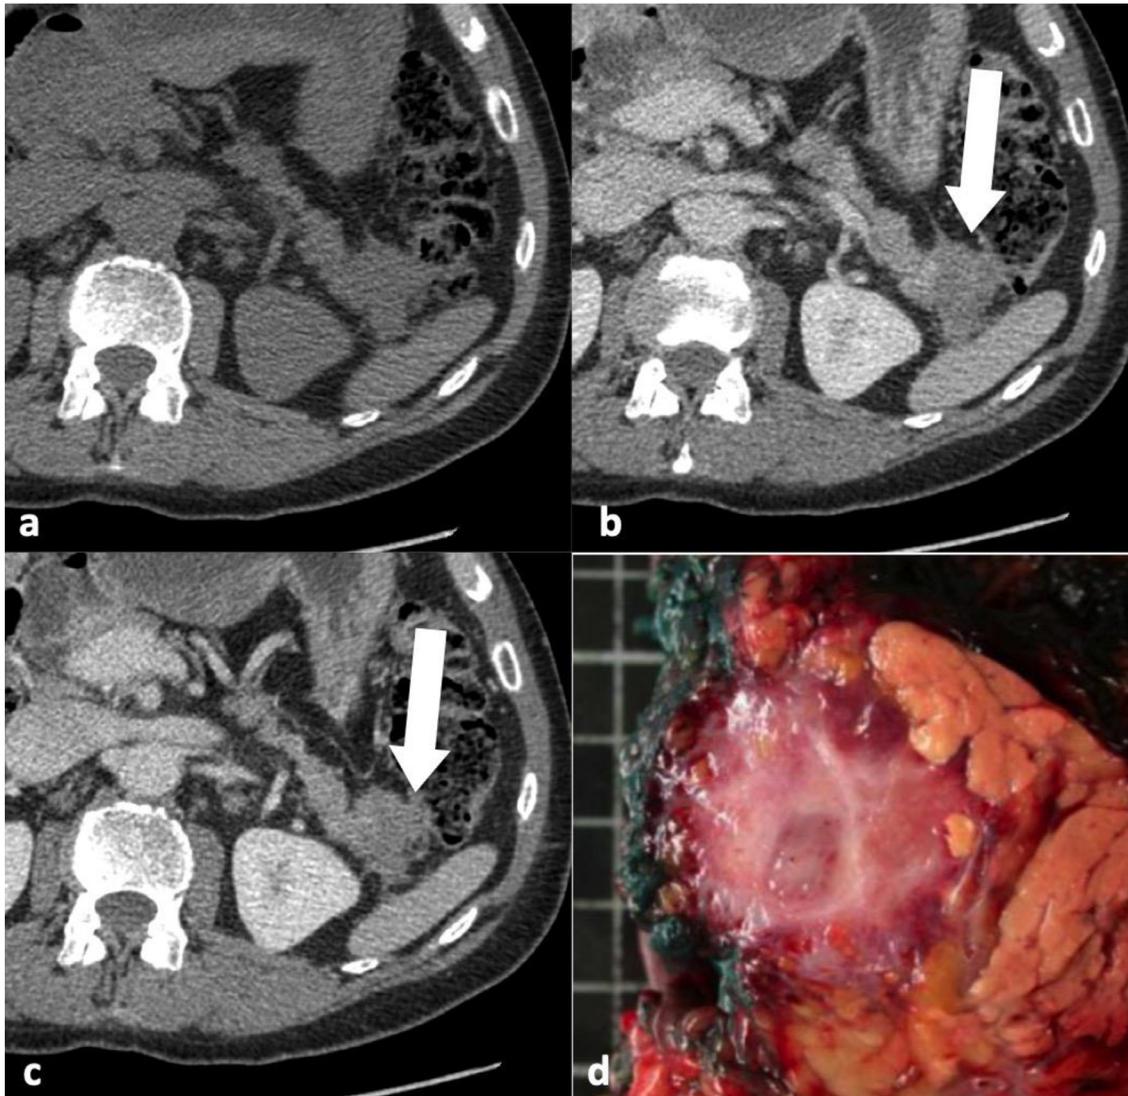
Desmoid tumor in a 67-year-old male patient with history of Hodgkin's lymphoma treated with chemotherapy. Precontrast (a) and contrast-enhanced (b, c) CT images show an infiltrative ill-defined lesion (arrow) of the pancreatic tail with progressive enhancement from the portal (b) to delayed 3' phase (c). The lesion was resected confirming the diagnosis of desmoid tumor (d).
